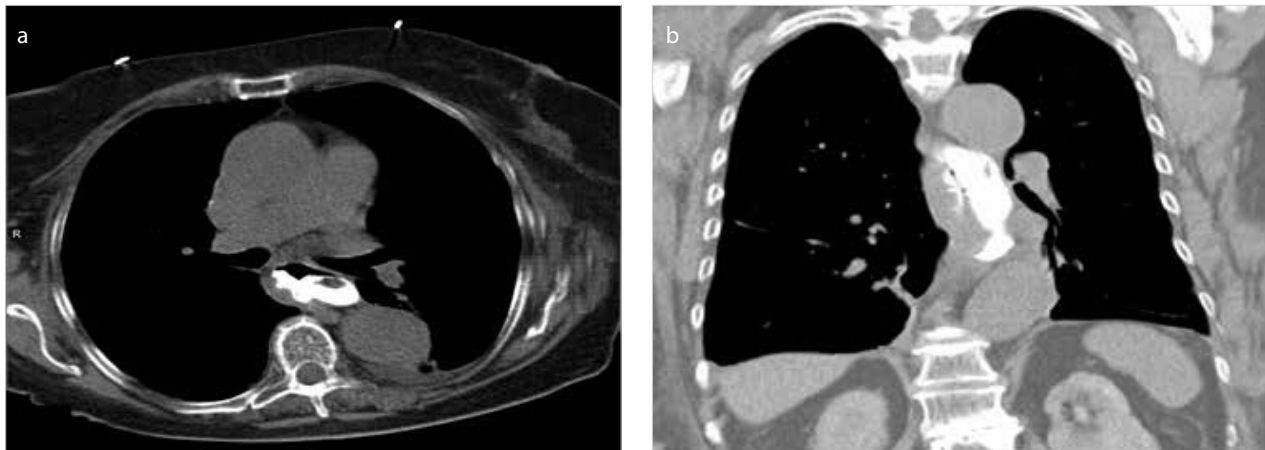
a, b. Double-lumen esophagus at the oral contrast-enhanced chest computed tomography scan. There was no mediastinal free air and contrast extravasation
